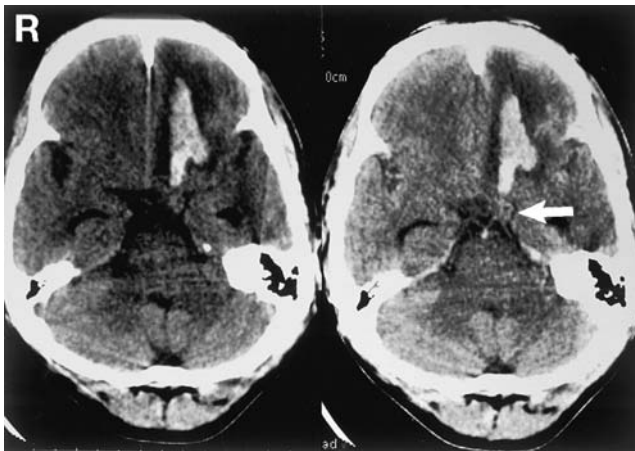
Computed tomography scans demonstrating intracerebral hemorrhage on the frontal base and slight enhancement (arrow) around the hemorrhage.
